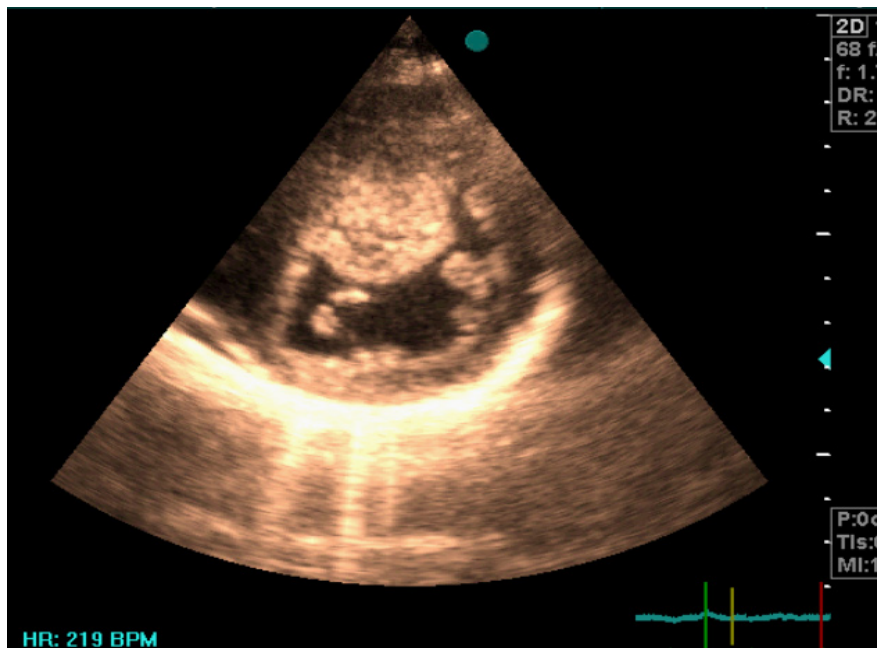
Transthoracic echocardiography in parasternal short axis view shows hydatid cyst in the interventricular septum.
